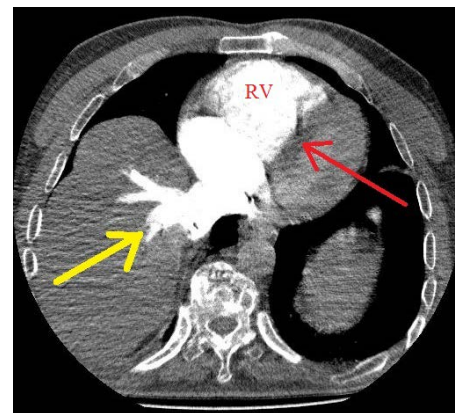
Red arrow points to straightened ventricular septum due to right ventricular (RV) strain which was confirmed later using echocardiography. Yellow arrow points to a back flow of contrast material into the hepatic veins.
